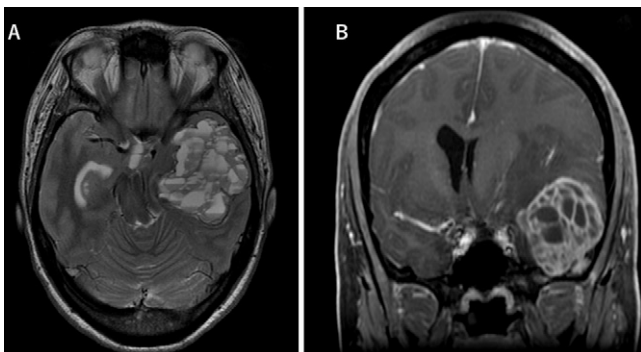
A: Axial T2-weighted MRI sequence showed a well-circumscribed extraaxial tumor in the left temporal fossa. Multiple cystic lesions were formed. B: Coronal postcontrast T1-weighted sequence showed strong peripheral and septal enhancement.
